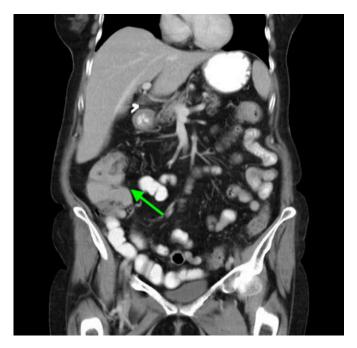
Preoperative CT scan of the abdomen showing ascending colon mass (see arrow) measuring 65 mm in diameter.
